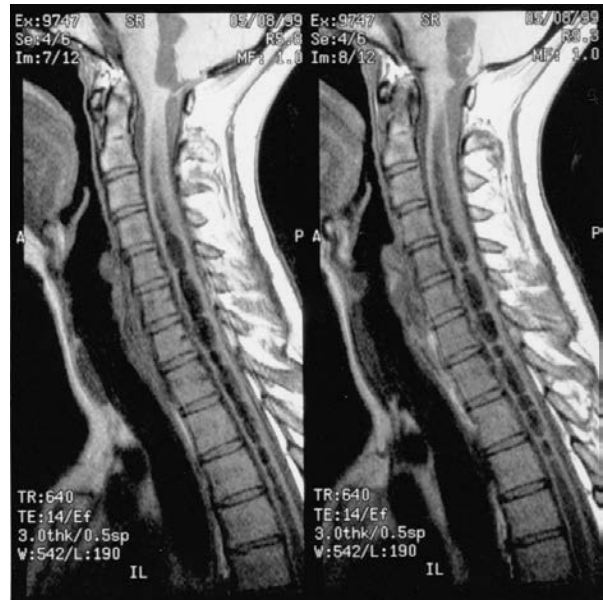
Magnetic resonance image of the cervical spinal cord and craniocervical junction in a 32-year-old woman with loss of pain and temperature sensation and a deep burning discomfort in the C4–8 dermatomes of both arms and a mild spastic paraparesis, showing an extensive syrinx throughout the cervical spinal cord, extending into the brainstem above and the thoracic cord below.
